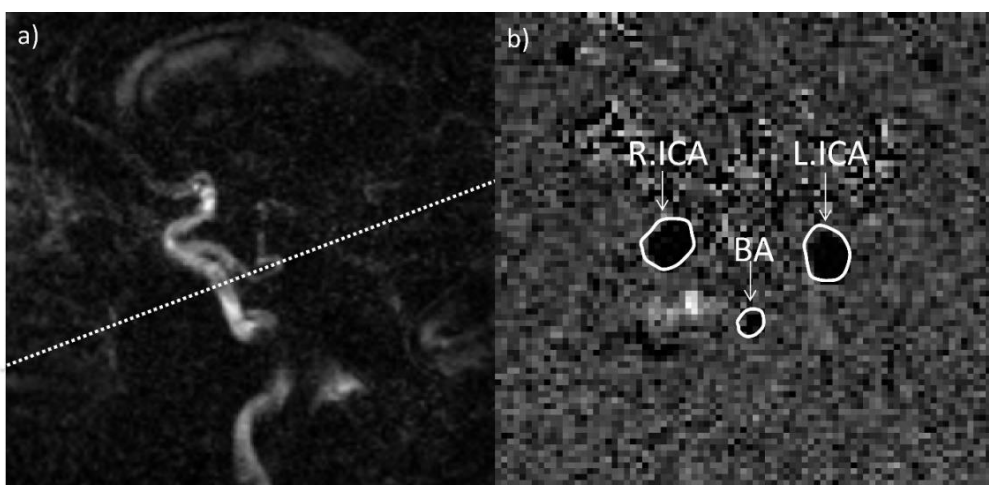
PC MRI for quantification of total cerebral blood flow.
